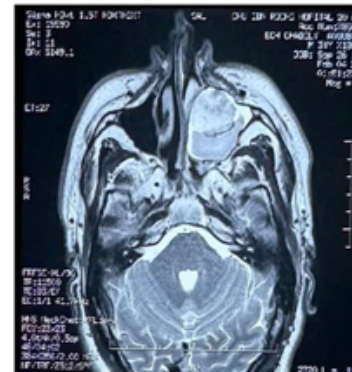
Axial MRI showing a heterogeneous hypervascular lesion centered within the left maxillary sinus.
